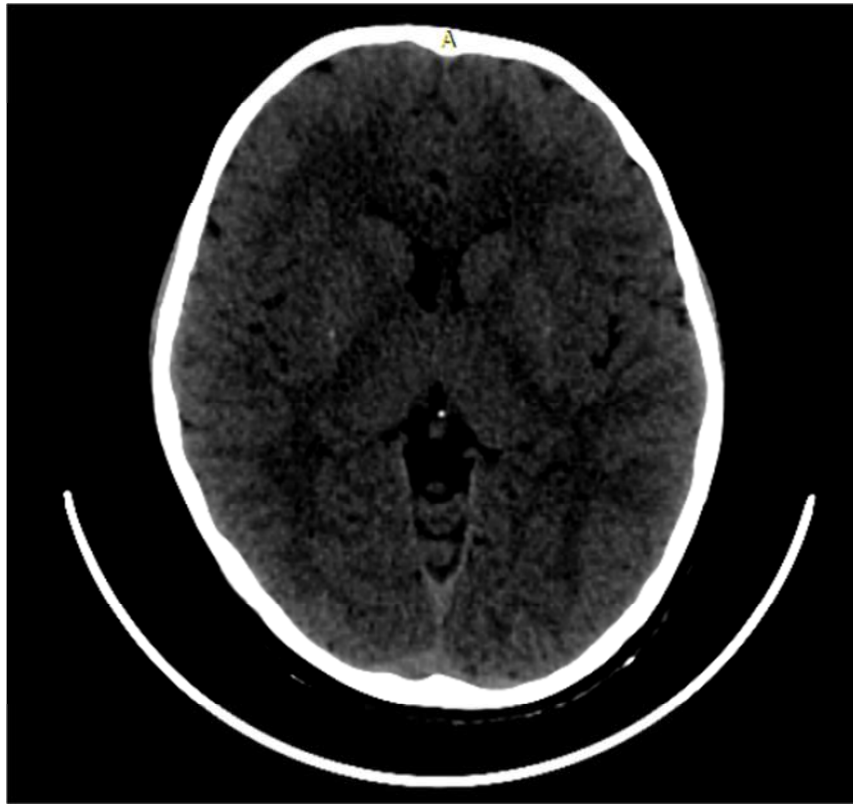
Axial CT image showing calcification in the right lentiform nucleus in a 9 year old male child with mineralizing angiopathy
